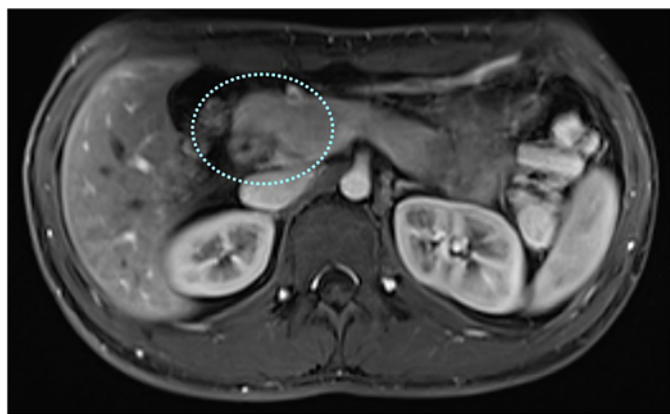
MRI scan with “crocodile jaw” appearance of the pancreatic head (dotted blue circle). MRI, magnetic resonance imaging.
